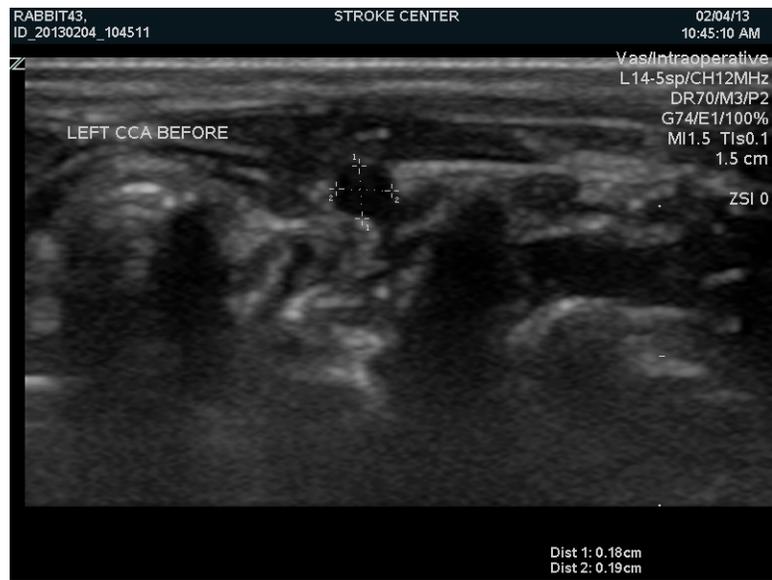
The ultrasound B mode is used to locate the vessel of interest. Vessel diameter is measured in this mode.
